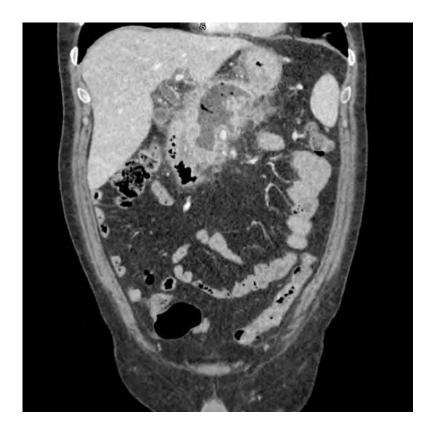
CE-CT scan performed four weeks after the onset of symptoms, demonstrating intrapancreatic walled-off necrosis with signs of infection (intra-necrotic air bubbles).
